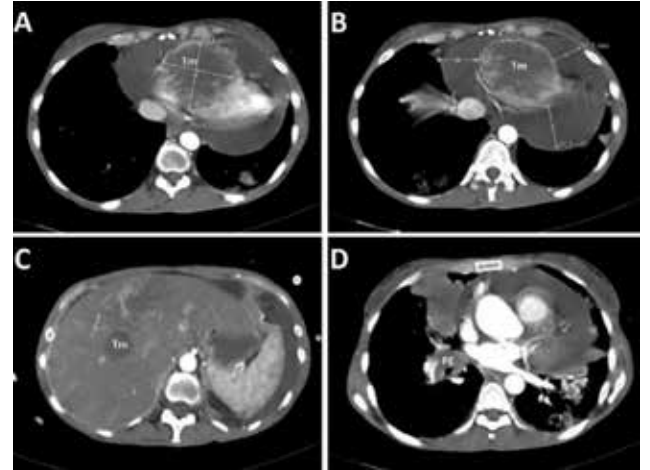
(A) Computed tomographic scan shows the giant mass in 6.26x6.85 dimensions filling the right ventricle. (B) Massive pericardial fluid. (C) Metastases in the liver. (D) Pulmonary tumor embolism.
